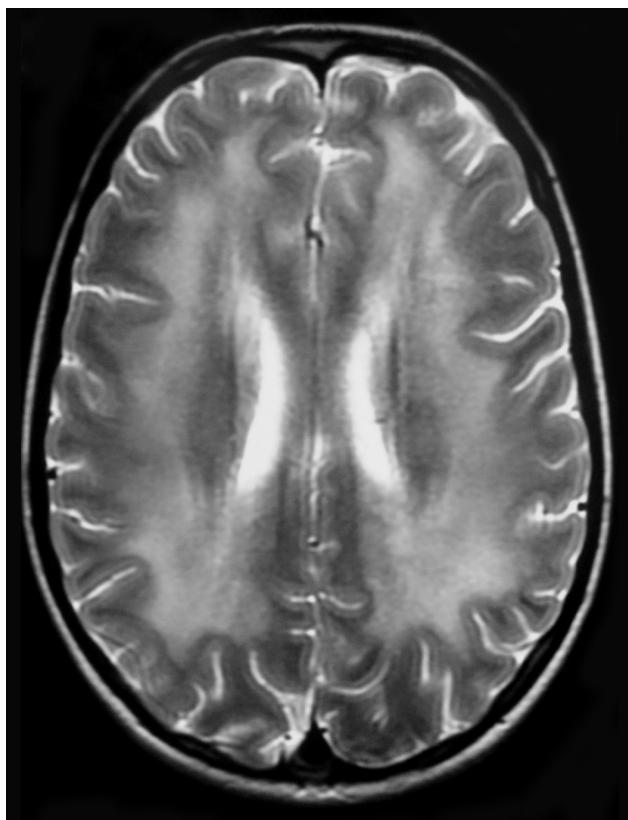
T2-weighted magnetic resonance imaging (MRI) of demyelination of deep white matter.
